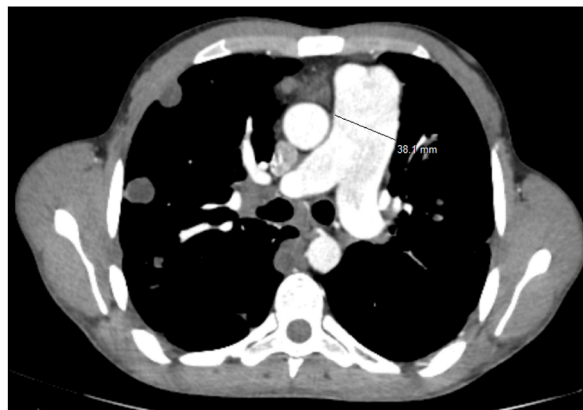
Axial post-contrast CT scan image: Enlarged pulmonary trunk – Main pulmonary artery to ascending aorta ratio  $>1$ .
